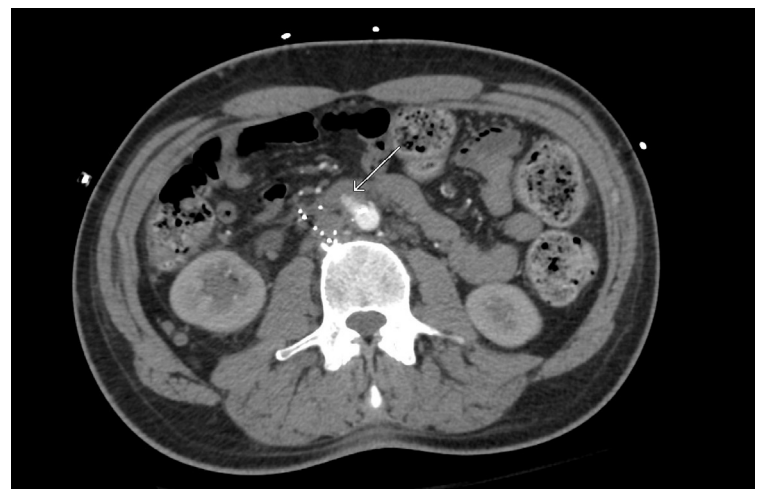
CT angiogram, axial view, showing an aortic pseudoaneurysm projecting into the wall of the third portion of the duodenum.
